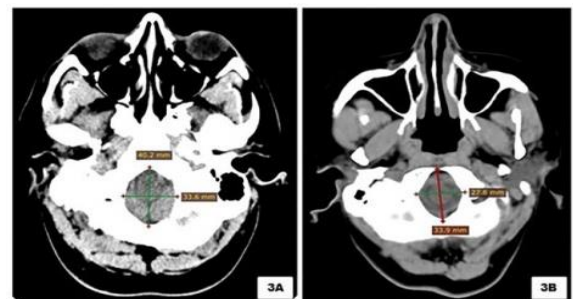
Computed tomography scan - axial view shows measurements of foramen magnum in male (fig. 3A) and female (fig. 3B) participant.
